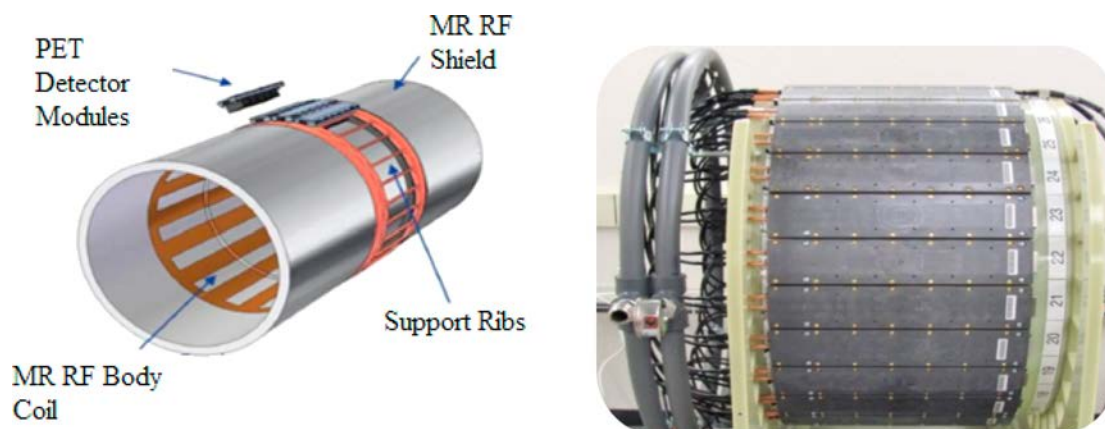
Structure of the GE Signa, the first integrated-TOF simultaneous PET/MRI system. Image courtesy of GE Healthcare.
